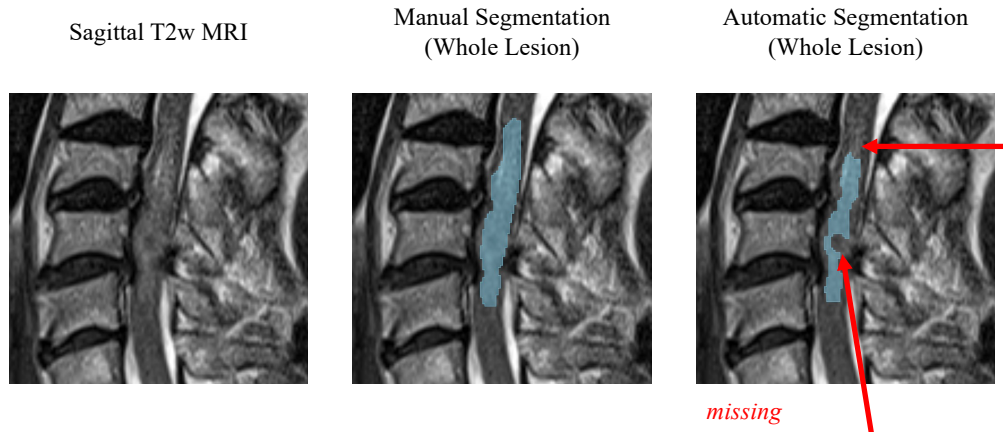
Comparison of Manual and Automatic Segmentation on Sagittal T2-weighted MRI
